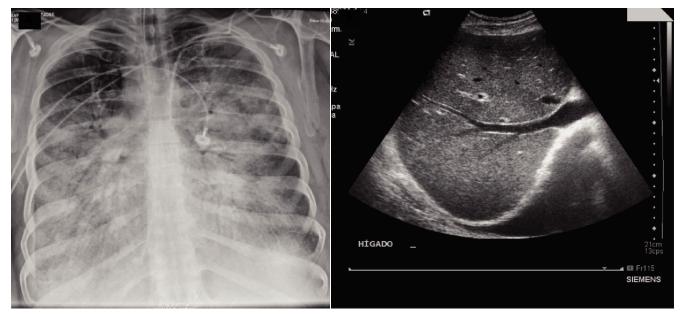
A. Chest X-ray showing disseminated heterogeneous opacities, B. Hepatic ultrasound showing a normal parenchyma and intrahepatic bile ducts.
